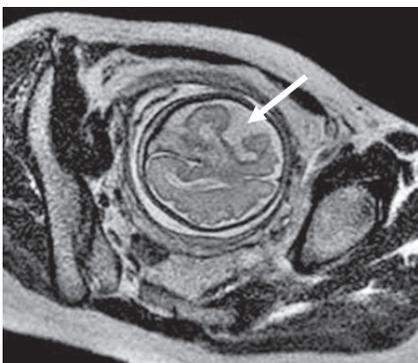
Case 18: Fetal MRI shows in utero destruction of the left cerebral hemisphere (arrow) in a 29-week fetus. Baby developed increased tone in right arm and both lower limbs but was able to walk at 2 years 3 months after physiotherapy.
